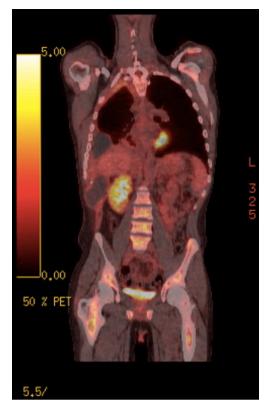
Positron emission tomography (PET)-CT showing fluorodeoxyglucose avid pleural-based soft tissue, and pleural thickening of the right lung apex is consistent with progression of the disease.
